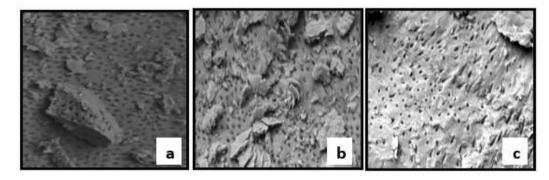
Group C – Conventional multistep irrigation with ultrasonic agitation; a) Coronal third; b) Middle third; c) Apical third
